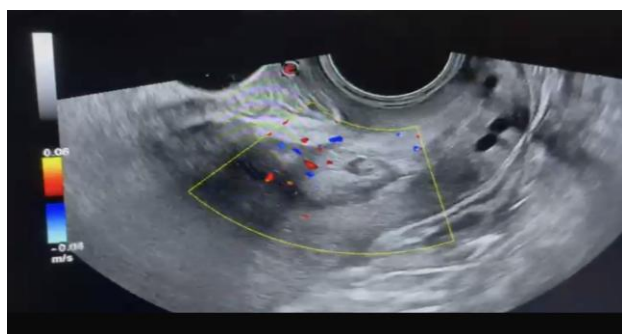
Ultrasound-guided intra-sac medical management of CSP.
